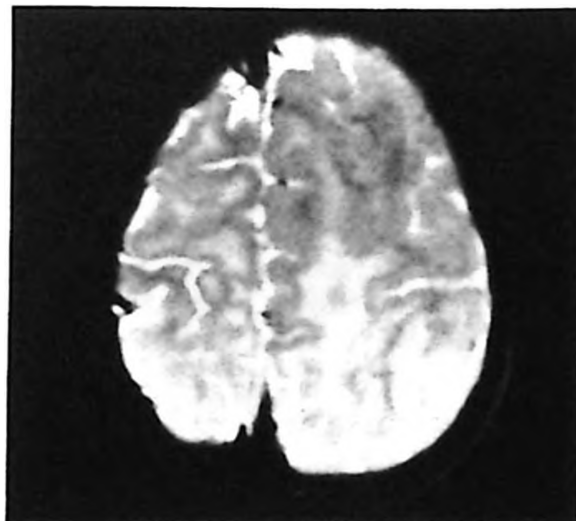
Magnetic resonance imaging of hemimegalencephaly.
